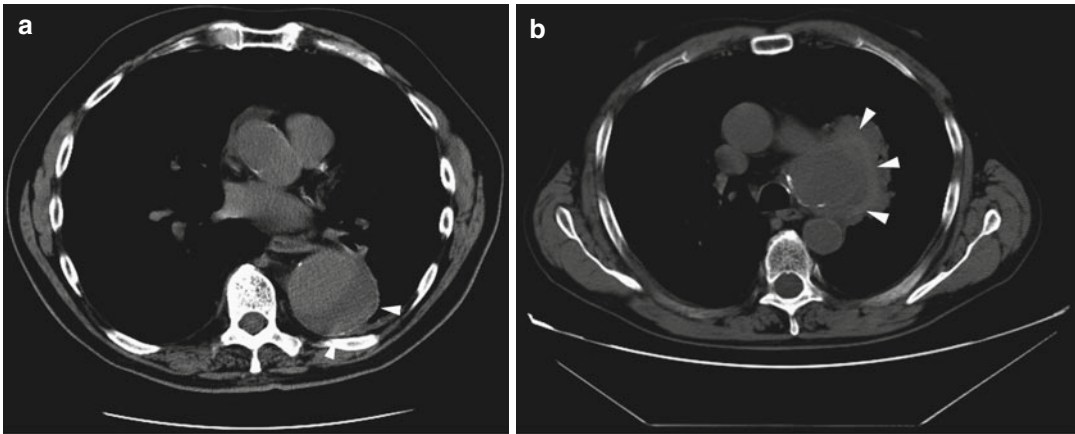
Unenhanced axial CT sections of a patient with contained rupture of aneurysmal descending aorta. The discontinuity of wall calcifications is clearly shown on the posterior and lateral side of aorta (*arrow heads*)
